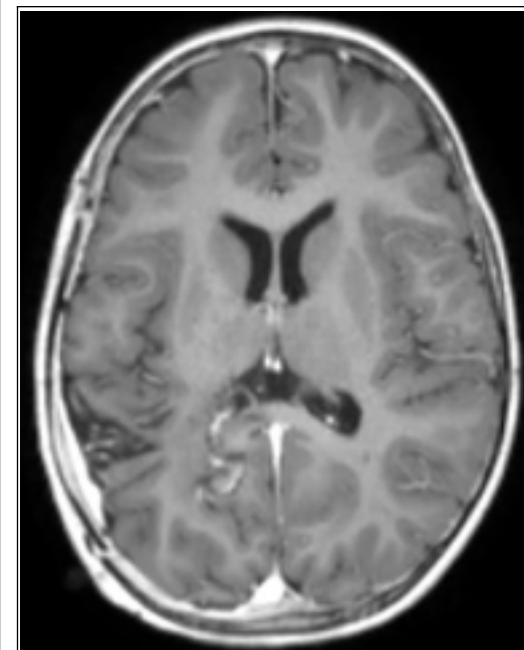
Three month post-operative MRI
